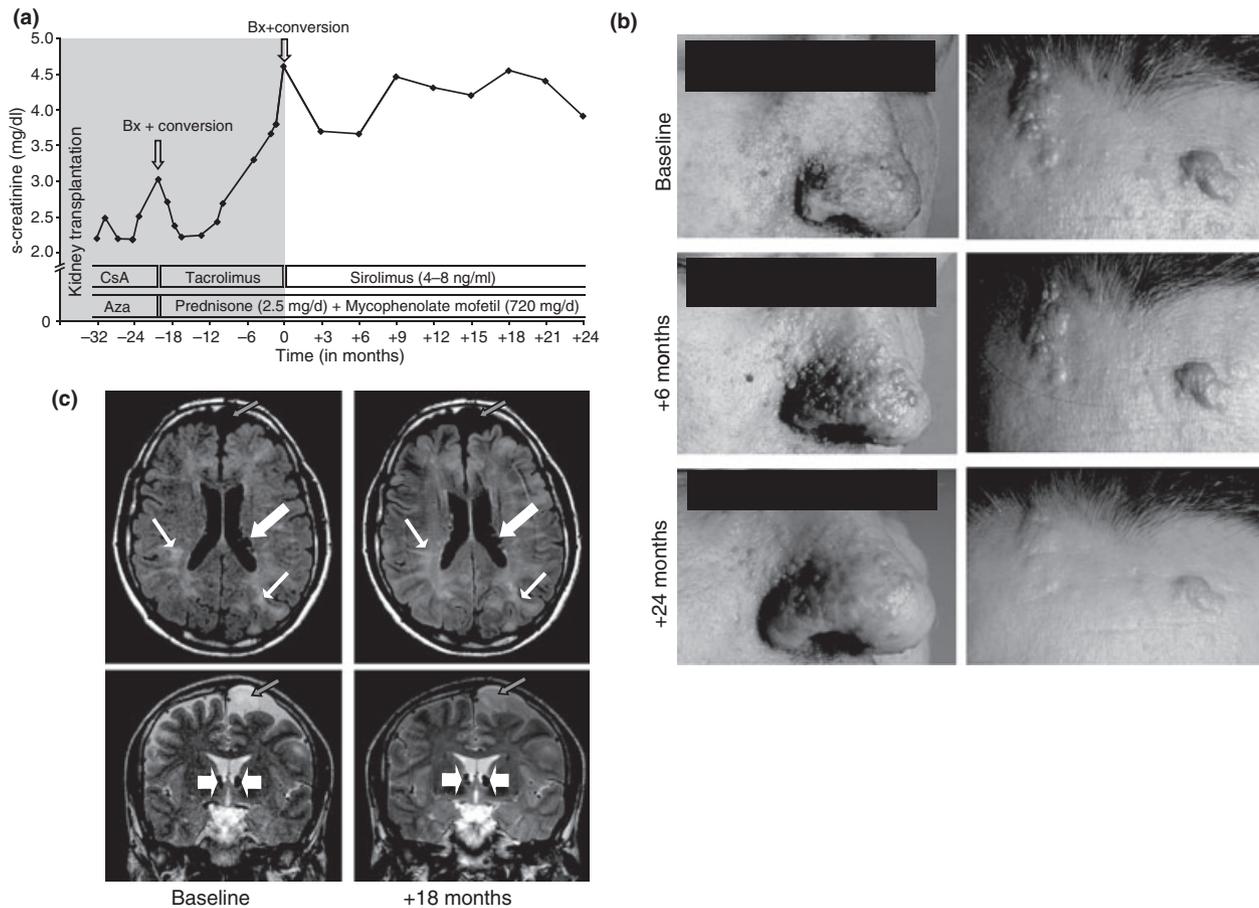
Patient 1 (a) Renal allograft function and immunosuppressive regimen. (b) Magnetic resonance imaging (MRI) scans of the brain before (baseline) and 18 months after conversion to sirolimus. Upper left: axial fluid-attenuated inversion recovery (FLAIR) sequence. Subependymal nodules in both ventricles, on the left side with cystic appearance (thick white arrow). Multiple subcortical tubera, hyperintense compared with adjacent grey/white matter (thin white arrows). Secondary finding: left frontal arachnoidal cyst (thin grey arrow). Lower left: Coronal view, T2-weighted sequence. Calcified (hypointense) giant cell astrocytomas at both foramina of Monro (thick short white arrow). Secondary finding: left frontal arachnoidal cyst (thin grey arrow). Upper right: Axial-FLAIR-sequence, 18 months after conversion to sirolimus: Unchanged in comparison to baseline. Lower right: Coronal view, T2-weighted sequence, 18 months after conversion to sirolimus: unchanged in comparison to baseline. (c) Facial angiofibromas and forehead plaques before, 6 and 24 months after conversion to sirolimus.
